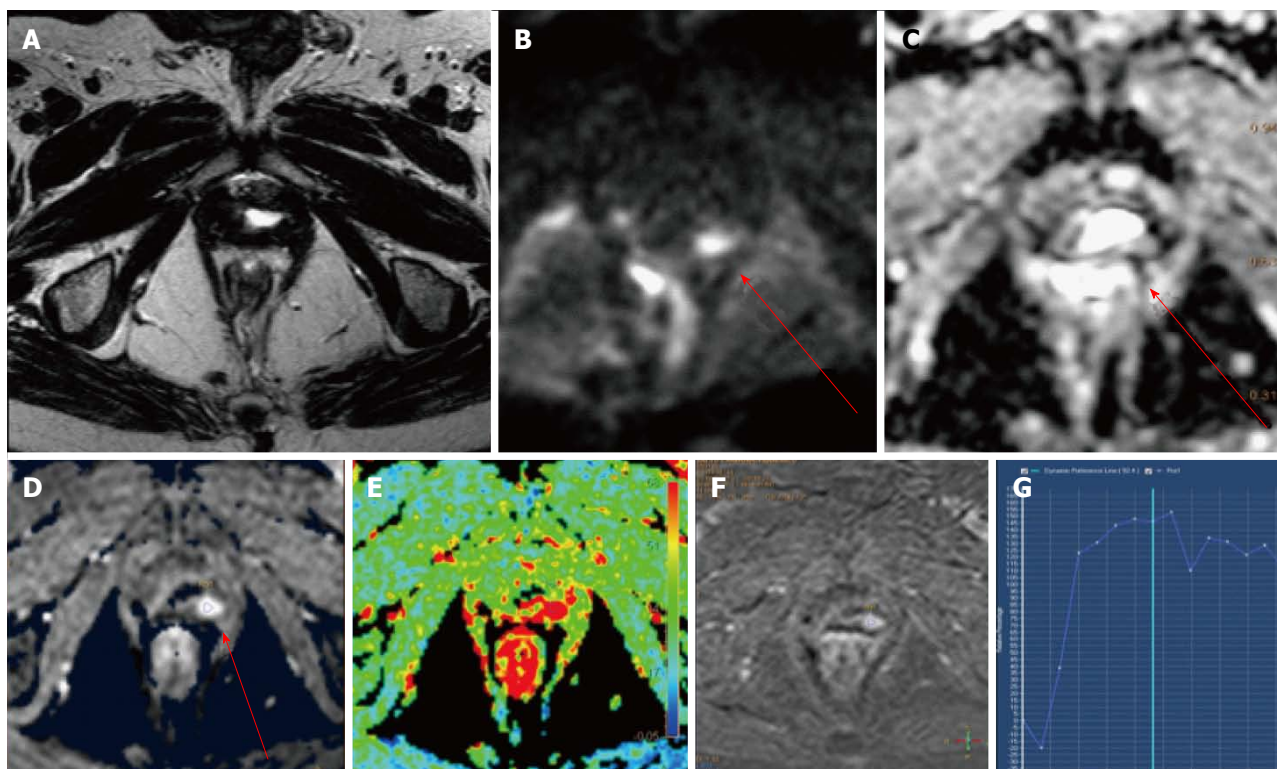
Multiparametric magnetic resonance imaging of local recurrence. A: Morphological study: Axial T2-weighted fast-spin echo image. No recurrence is detected; B-F: Functional study; B and C: Axial diffusion sequences showing restricted diffusion in ADC map (arrow); D-G: Axial gradient-echo T1-weighted images showing focal enhancement in dynamic study (D) (arrow), color map (E) and curve (G).
